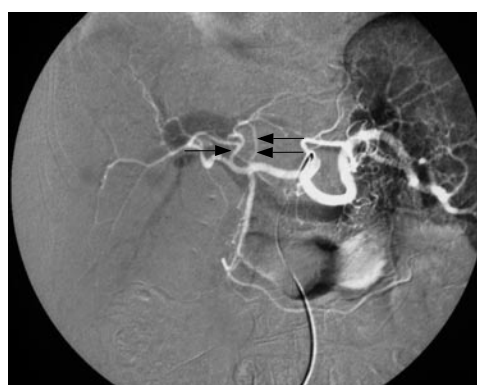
A 50-year-old woman with chronic hepatitis C. Right trisegmentectomy and cholecystectomy were performed due to the right lobe liver tumor. A: US demonstrated a club-shaped portal vein (arrow) over the right lobe of the liver and no umbilical portion over the left lobe of the liver; B: Enhanced CT demonstrated enlarged left lateral segment and a club-shaped portal vein (arrow) over the right side of the liver; C: Angiography demonstrated trifurcation type of the portal vein; D: Intraoperative photography demonstrated gallbladder over left side of ligamentum teres and adhesions on the left lateral segment (arrow).
